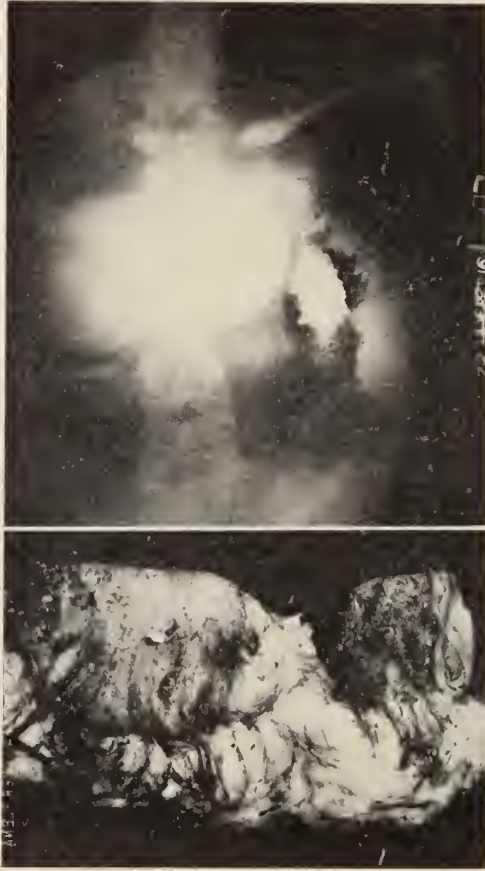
(Upper). X-ray studies of small bowel showing enormous dilatation proximal to site of fecal fistula. At this point the bowel was almost completely divided by the marked stenosis.
